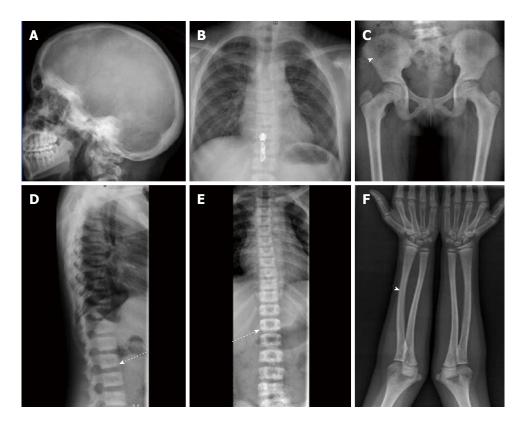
Skeletal survey. Note generalised increased bone density in all the radiographs (A to F). Calvarial bones as well as skull base are thickened (A), lung fields are normal with sclerotic ribs (B). No paraspinal masses to suggest extra medullary hematopoiesis. Sclerosis of pelvic bones with subtle blurring of cortico-medullary is differentiation in long bones (arrow heads). Sclerosis along vertebral endplates (dotted arrow) leading to "rugger jersy spine" (D and E).
